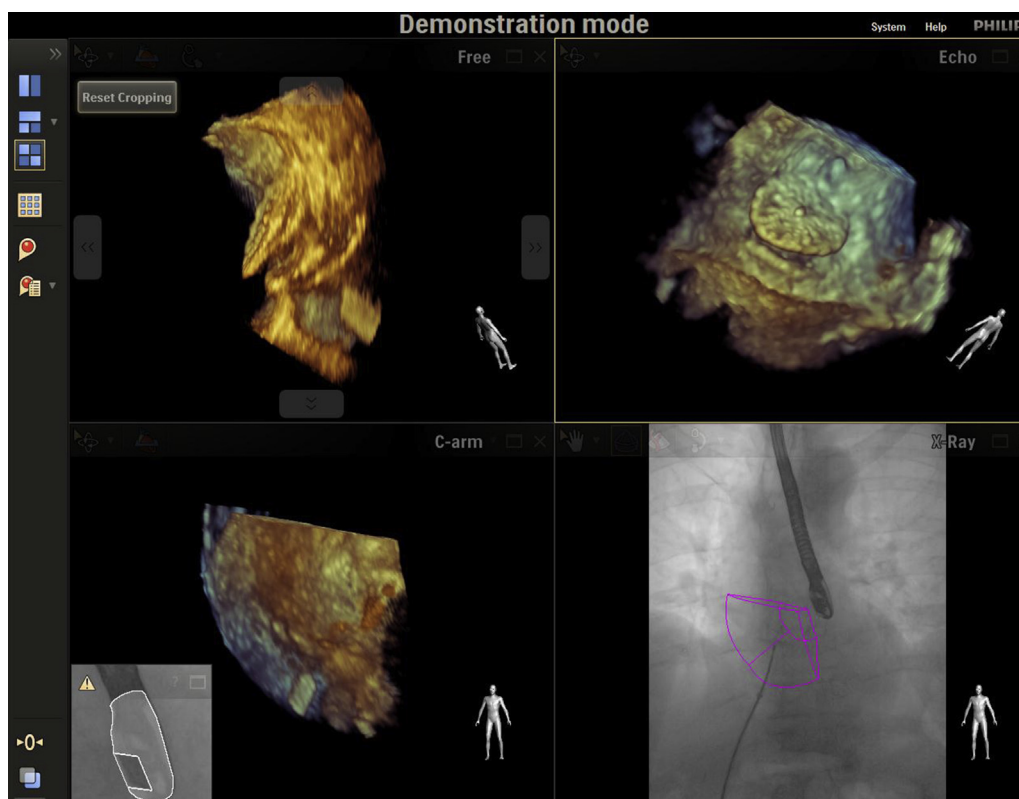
With the Echonavigator, we succeeded in aligning two different imaging modalities, putting the X-ray and echo onto the same coordinate system. With this system, the position of the TEE probe is registered to the X-ray c-arm and 2D/Xplane/3D TEE images are linked and updated with fluoroscopic views. In the present example of atrial puncture, a marker (red plot) is placed at the puncture site. Markings on soft tissue anatomical structures in Echo appear in the X-ray for context and guidance. Echo and fluoroscopic images confirm the marker position. The wire (red arrows) is pulled down to the interatrial septum. X-plane 2D images help identify "tenting of the septum" (thin red arrow). (Images are courtesy of Philips Healthcare).
